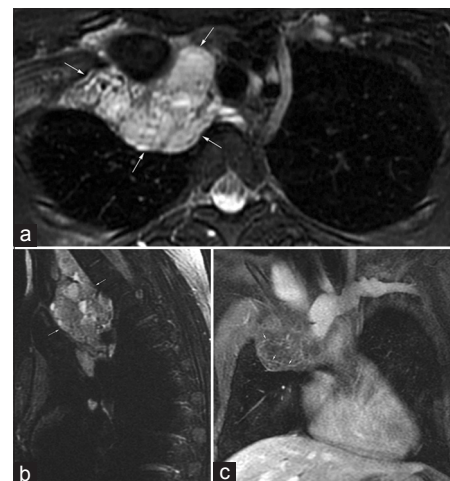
25-year-old female with chromosomal abnormality, mediastinal mass, and severe combined pectus excavatum and carinatum deformity. (a) Axial and (b) sagittal T2-weighted images demonstrate a multilobulated, multiseptated cystic mass (arrows) with multiple fluid-fluid levels in the right side of the superior mediastinum extending into the right side of the neck and to the junction of the superior vena cava and the right atrium. (c) Coronal postcontrast T1-weighted image demonstrates thin septal enhancement (arrows). Findings are consistent with a large lymphatic malformation for which the patient had previously undergone surgery.
